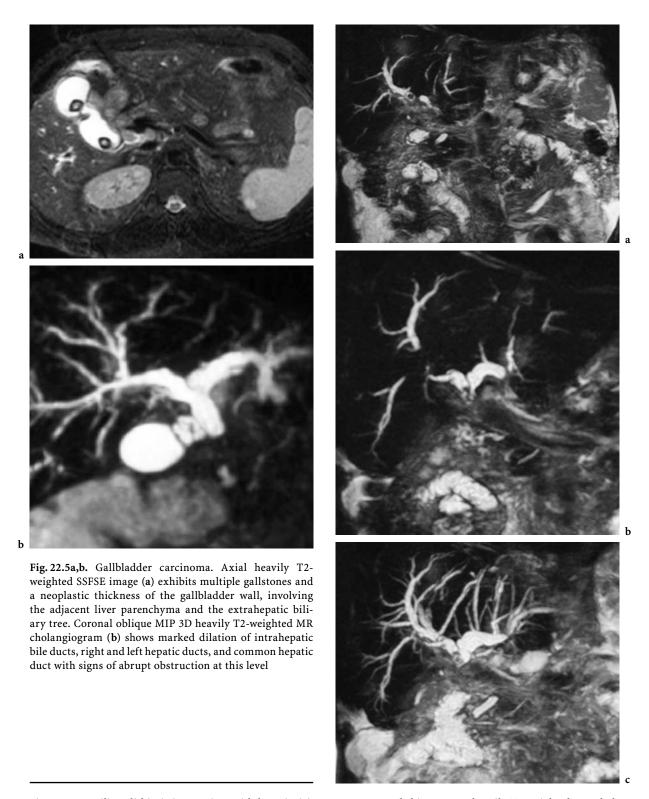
Biliary lithiasis in a patient with hepaticojejunostomy. Coronal thin MIP 3D heavily T2-weighted MR cholangiograms (a,b) show the presence of multiple stones into both the right hepatic duct and the pre-anastomotic common hepatic duct. Coronal thick MIP 3D heavily T2-weighted MR cholangiogram (c) better shows the dilation of the intrahepatic biliary system, the right and left hepatic ducts and the common hepatic duct
